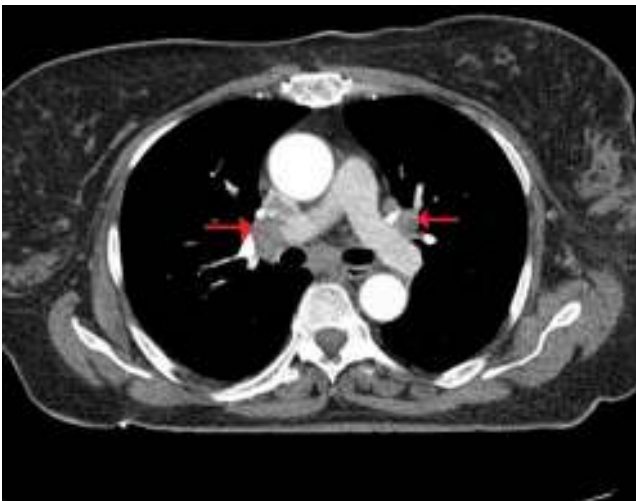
Torax computed tomography showed bilateral hilar and mediastinal lymphadenopathies.
